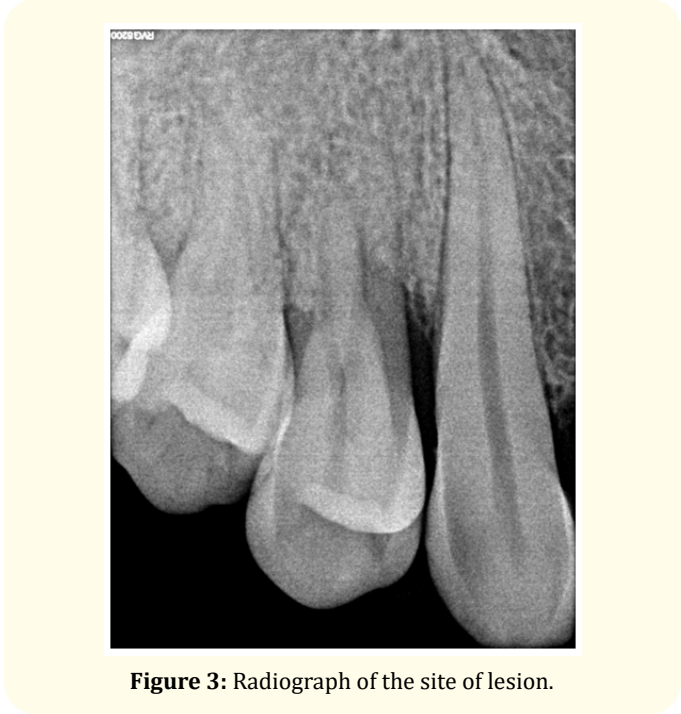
Radiograph of the site of lesion.
